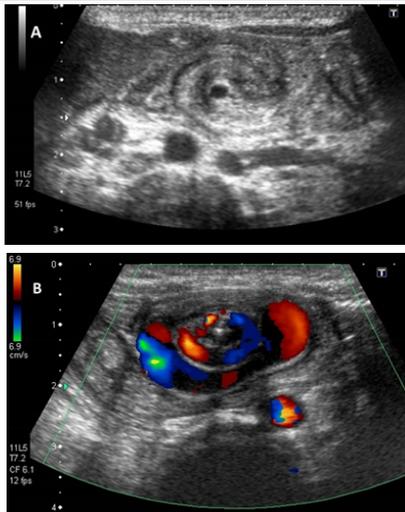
(A): Longitudinal US image of a 1 year old child with right iliac fossa pain, reveals telescoping of the intussusceptum into the intussuscipiens. (B) Transverse sonogram reveals 'target' or 'doughnut' appearance of intussusception.
